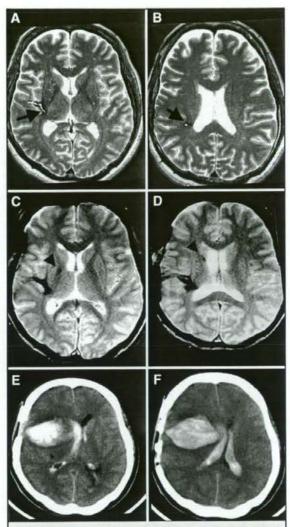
A and B, another case of MBs exhibited subsequent symptomatic hemorrhage. A 49-year-old woman with MMD had a history of previous ICH in the right temporal lobe. Arrows indicate MBs; asterisks indicate previous hematoma. Unsuccessful direct bypass surgery was performed on the right side. Subsequently, the patient presented with frequent transient attacks of bilateral motor weakness and was admitted to our institute. C and D, on admission, a T2\*-weighted imaging study was performed with a 3-T MRI unit revealing multiple asymptomatic MBs in the right caudate putamen that were not contiguous with the previous hematoma (arrowheads). Recurrent ICH occurred 6 months after surgery. However, recurrent ICH occurred on the day of discharge. E and F, the hematoma had apparently originated not from the site of the previous hemorrhage, but from the site where the MBs had been revealed.
